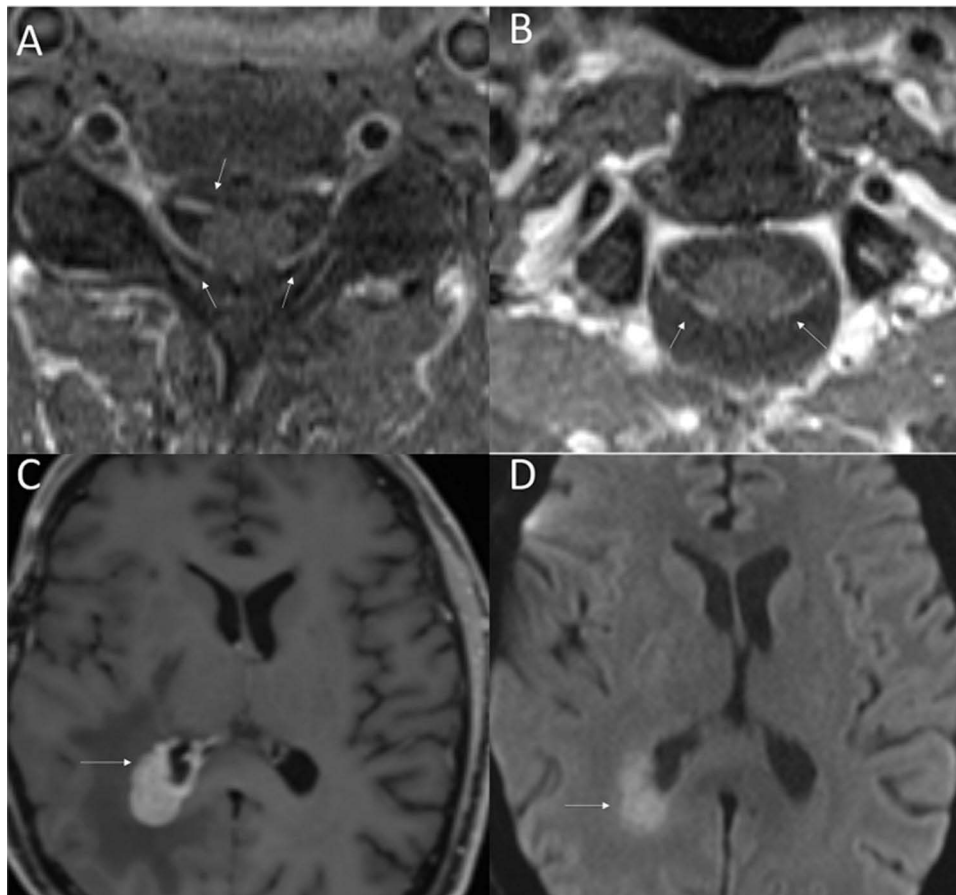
Follow up MRI of the cervical spine (A and B) and brain (C and D) after 1-year of initial presentation with progression of neurolymphomatosis. Axial (A and B) contrast-enhanced T1-weighted MR images of the cervical spine with thickening and enhancement of multiple dorsal and ventral nerve roots. Contrast-enhanced T1-weighted MRI of the brain reveals nodular enhancing lesion with ependymal involvement in the right peritrigonal region (C, arrow). Lesion shows restricted diffusion (D, arrow) suggesting high cellularity.
